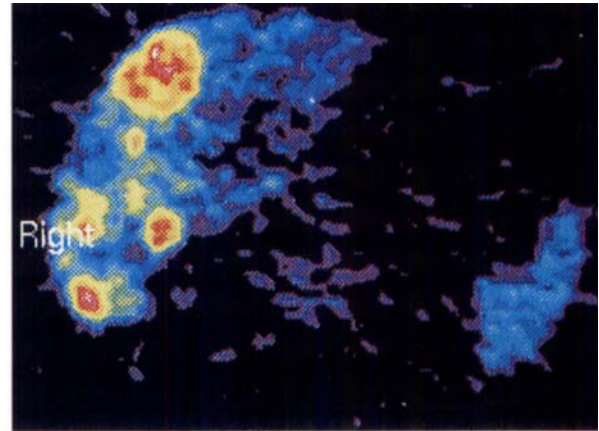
Patient with an ileal carcinoid (case No. 2), multiple liver and also abdominal lymph node metastases investigated with ^{11}C PET (3a). 5-HTP is taken up in apparently all the liver metastases and also a lymph node metastases adjacent to the pancreas. A CT-scan is shown for comparison (3b).
